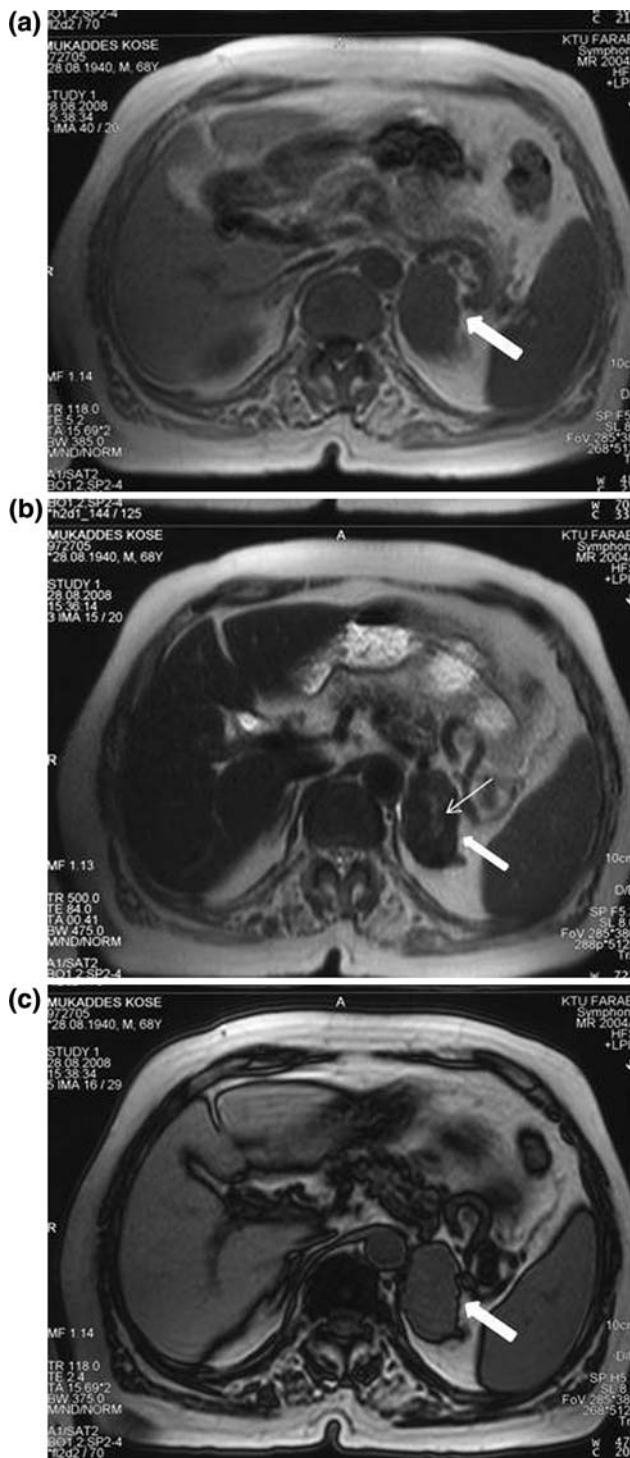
a Transverse T1-weighted MRI shows an oval, slightly lobulated left adrenal mass that measures 60 × 45 mm (*arrow*). The mass is homogeneous, with signal intensity less than that of liver (hypointense). b Transverse T₂-weighted MRI scan demonstrating oval heterogeneous mass (*thick arrow*) with slightly high signal intensity greater than that of liver and with central crescent-shaped calcifications in adrenal mass (slightly hyperintensity) (*thin arrow*). c Out-of-phase MRI not showing significant signal loss in the lesion when compared with in-phase MRI (*arrow*)
